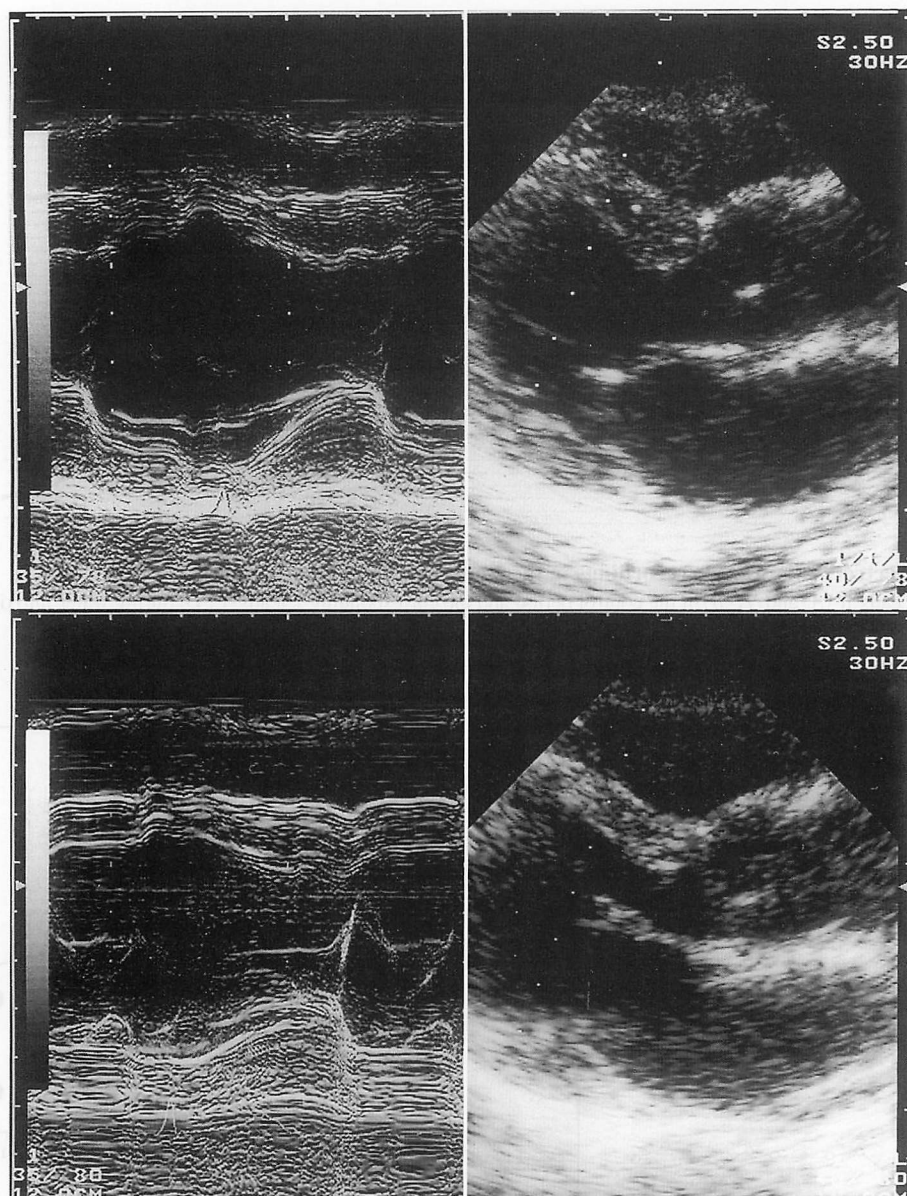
M-mode (left) and two-dimensional (right) echocardiograms
